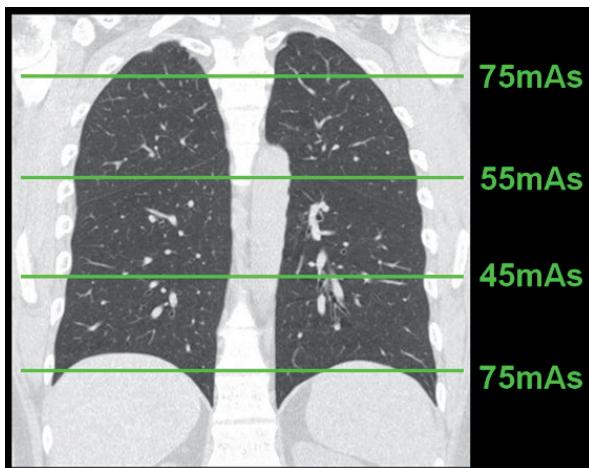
The SPR can be used to achieve AEC during the CT scan. The mAs values are indicated at four levels, but during the helical acquisition, the tube charge is continuously optimized at each level within the scanned range.
